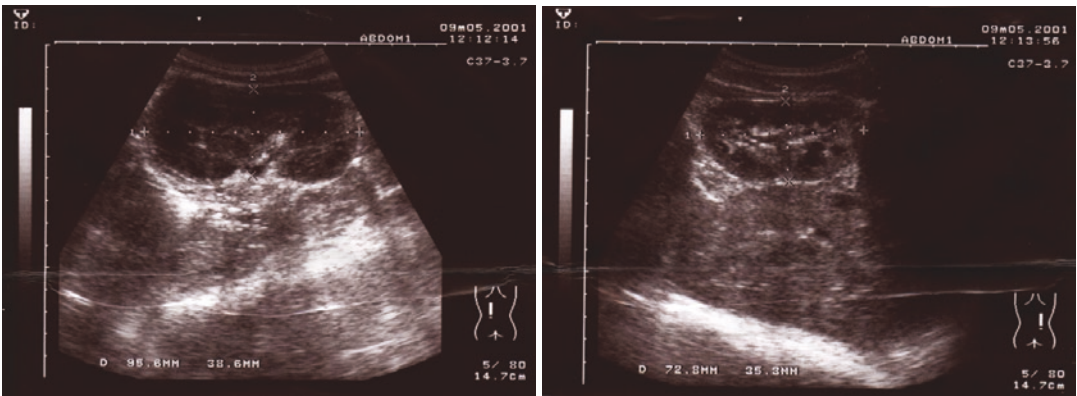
The renal ultrasonography images showed an enlarged left kidney (9.56 cm × 3.86 cm) and a normal-sized right kidney (7.28 cm × 3.53 cm)
